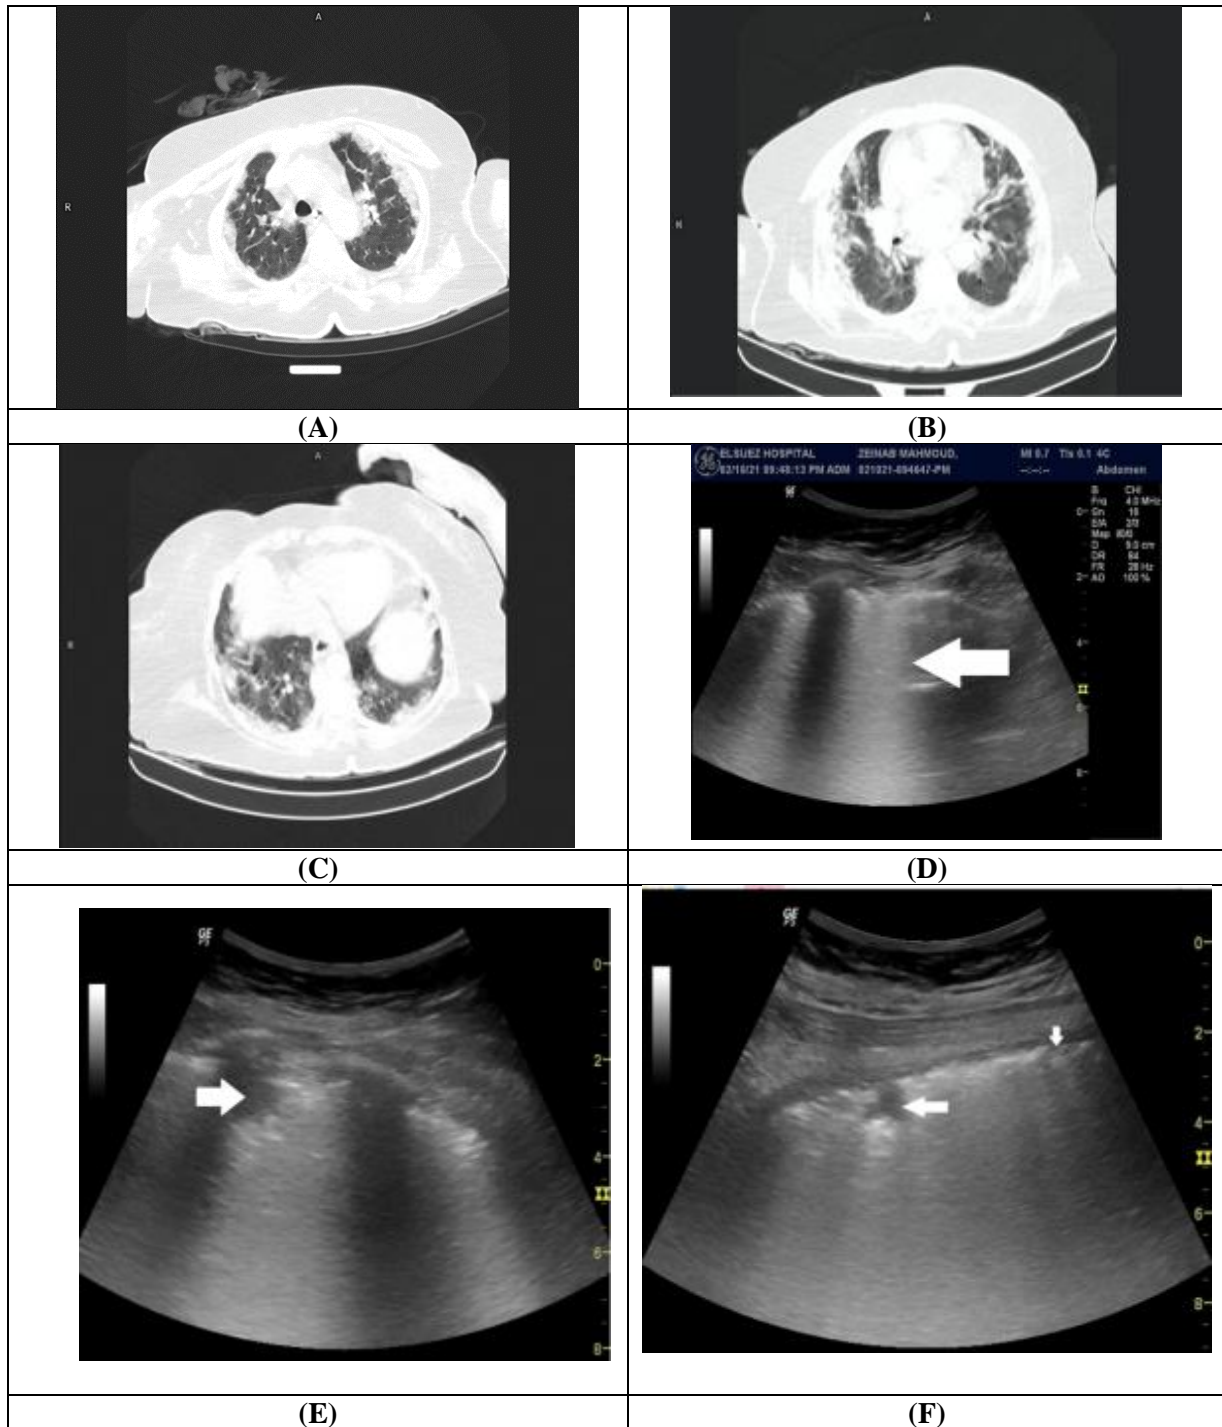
A 63-year-old female patient with COVID-19 symptoms science 21 days, HRCT (figure a to c) shows bilateral upper and lower lung lobes subpleural sheets of irregular consolidation with interstitial septa thickening. US reveals d) Completely fused B-lines (arrow). e) Subpleural echogenic area (tissue pattern) representing consolidation patch (arrow). f) Subpleural echogenic area (tissue pattern) representing consolidation patch (long arrow). The pleural line was thickened and interrupted (short arrow).
